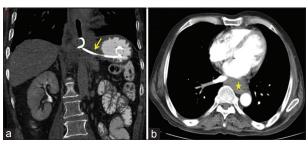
Coronal (a) and axial (b) sections of contrast-enhanced computed tomography (CT) contrast enhanced multidetector CT scan of the chest following endoscopic cystogastrostomy with drainage tube *in situ* (arrow) showing near complete resolution of the posterior mediastinal pseudocyst (star)
